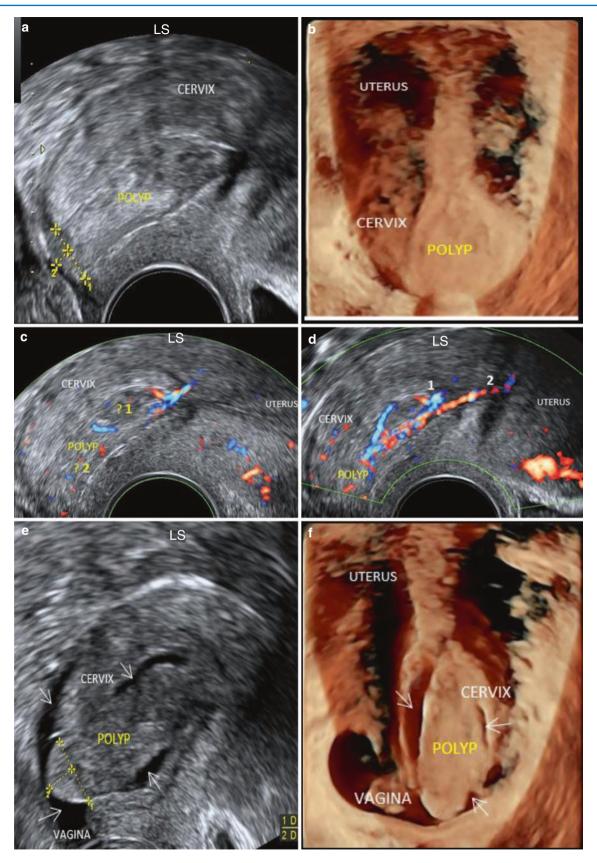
Polyp in the cervical canal which is protruding out from the cervical os. (a-d) Are images on regular TVS. The polyp is seen in the cervical canal (a) on 2D and (b) 3D. The lower margin of the polyp is seen protruding out of the external os. (c, d) On Doppler, there was a suspicion of two polyps (labelled as 1 and 2) because of the vascular pattern of flow with two vessels approaching the polyp (one venous and one arterial) from two different locations above the polyp. (e, f) Images on GSV. Single polyp is better seen and delineated on 2D and 3D with GSV
